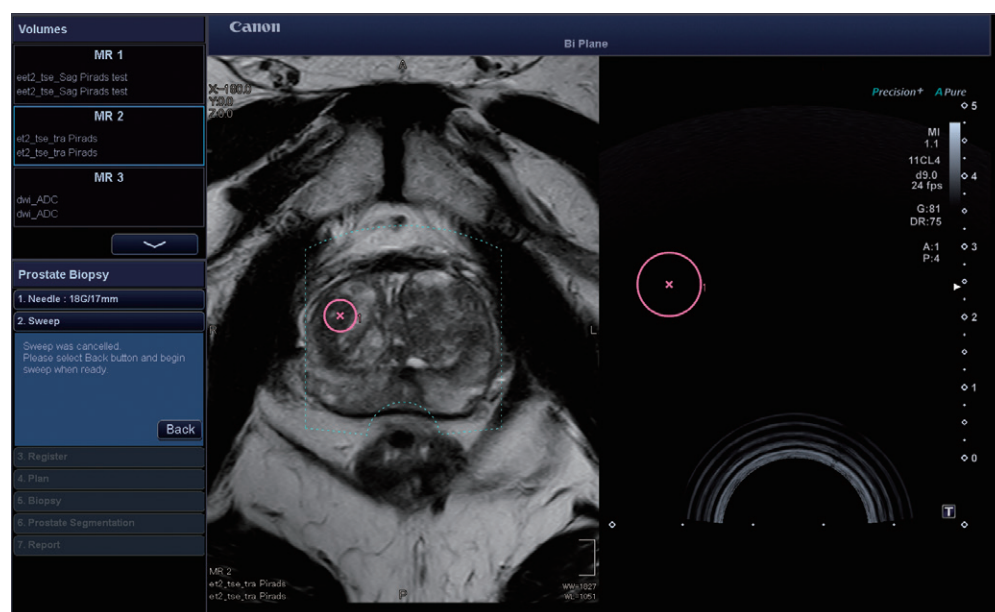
Review of the pre-loaded MRI dataset can be directly done on the ultrasound machine.
